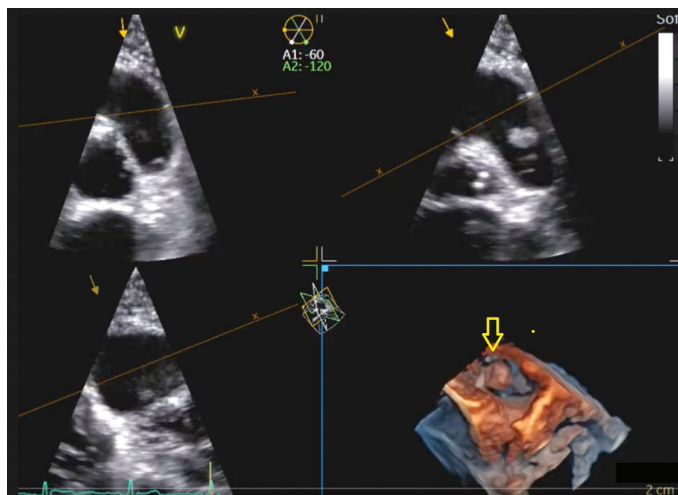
Live/real-time, three-dimensional, transthoracic echocardiography of the pulmonary valve that was acquired with a Ge Healthcare Vivid E95, using a 4Vc transducer, and processed with EchoPAC 204. The short-axis en face view shows a pedunculated, well-circumscribed, and homogeneous mass attached to the pulmonary valve (arrow).
